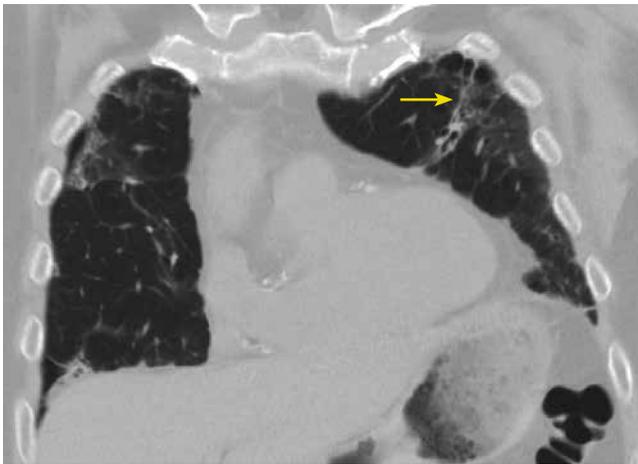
Coronal slice (lung window) of chest CT in a patient recovering from COVID-19 with persistent fatigue and shortness of breath. Abnormal findings of the lungs shown here include patchy, peripheral opacities with focal left upper lobe traction bronchiectasis, indicating the fibroblastic phase of viral organising pneumonia (arrow).
